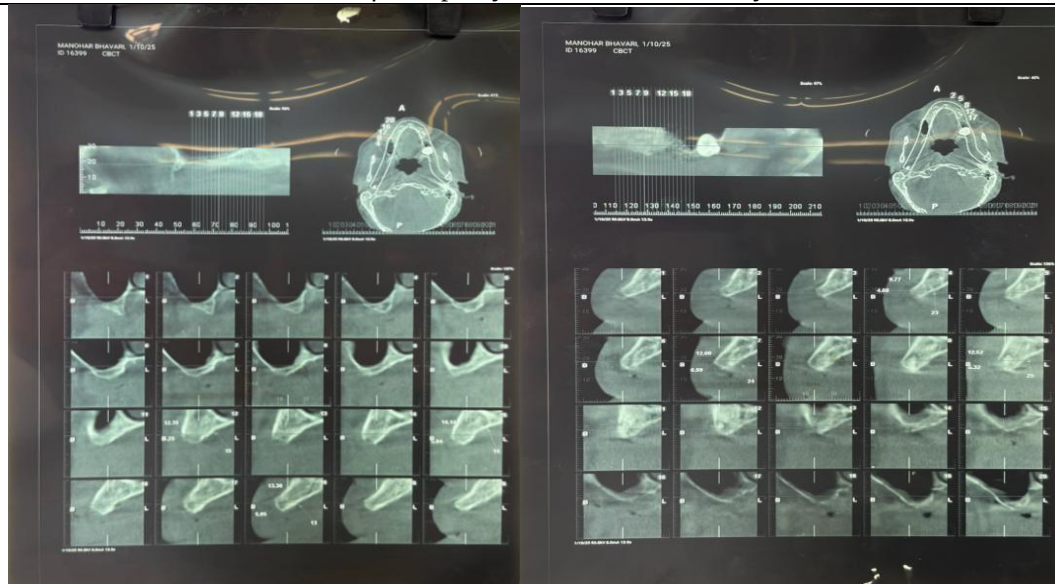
Additional CBCT cross-sectional views used for implant-site selection.
